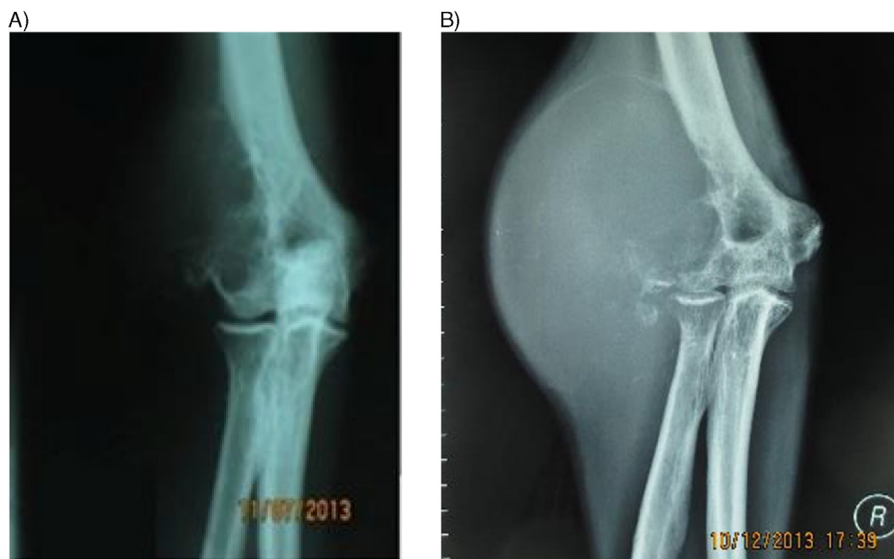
Elbow radiographs: (A) a destructive lytic lesion on the lateral side of the humerus through the lateral condyle with osteoid matrix formation (before neoadjuvant chemotherapy); (B) After neoadjuvant chemotherapy, the tumor mass became bigger.
